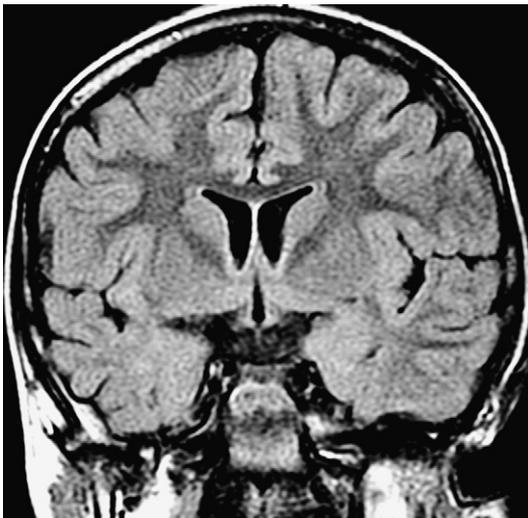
mMCD (formerly microdysgenesis). This coronal FLAIR image demonstrates a loss of white matter signal in the temporal lobe and a small right hemisphere. After surgery, pathology disclosed mMCD (although the diffuse atrophy would rather suggest FCD I).
